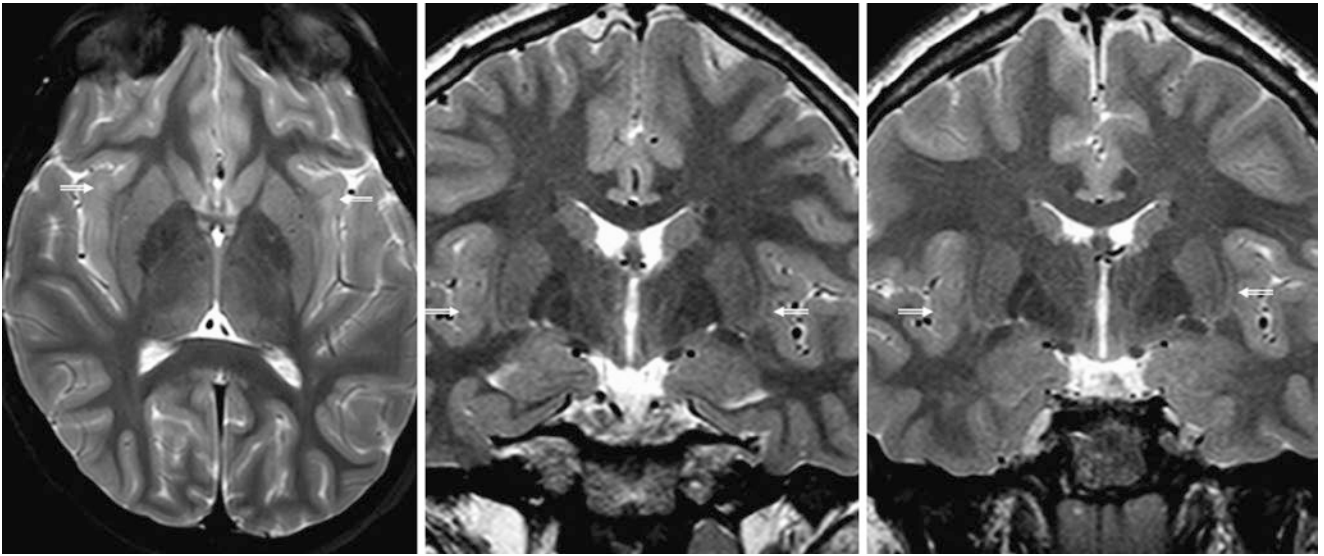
An 11-year-old with headaches had a normal 3T MRI that showed bilateral subtle terminal zones within the SIWM (*beveled arrows*) on axial (*left*) and coronal (*middle*) SE T2WIs. On a follow-up coronal SE T2WI MRI 4 years later (*right*), there is decreasing SIWM hyperintensity
